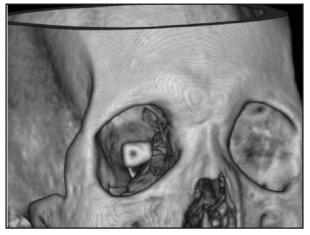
3-D CT scan showing the OOKP in the right socket.
